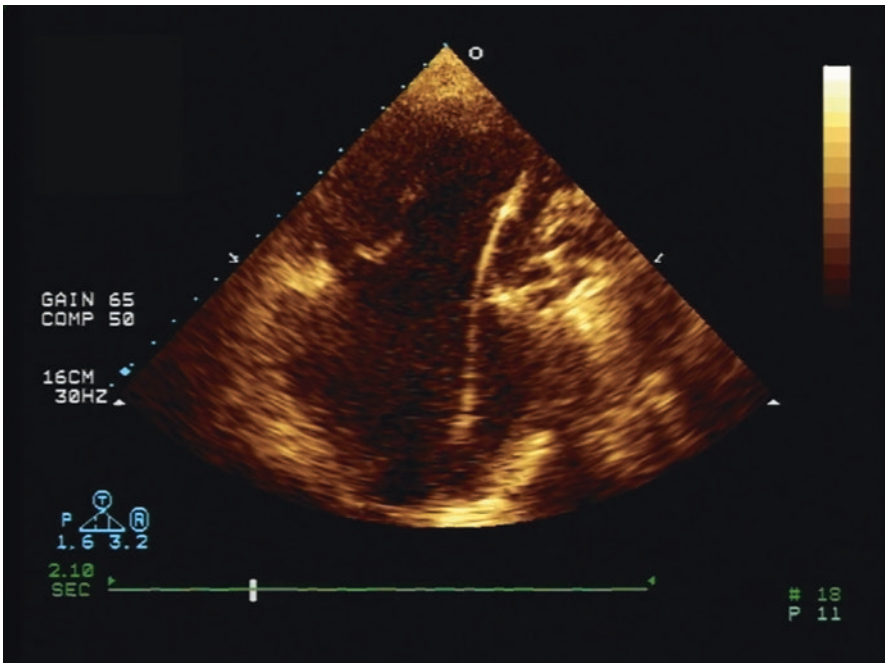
Transthoracic echocardiography depicting a modified projection for RV which shows the complete lead path within right cavities in a patient with inactive rheumatic cardiopathy, mitral prosthetic mechanical valve, and total hip replacement
